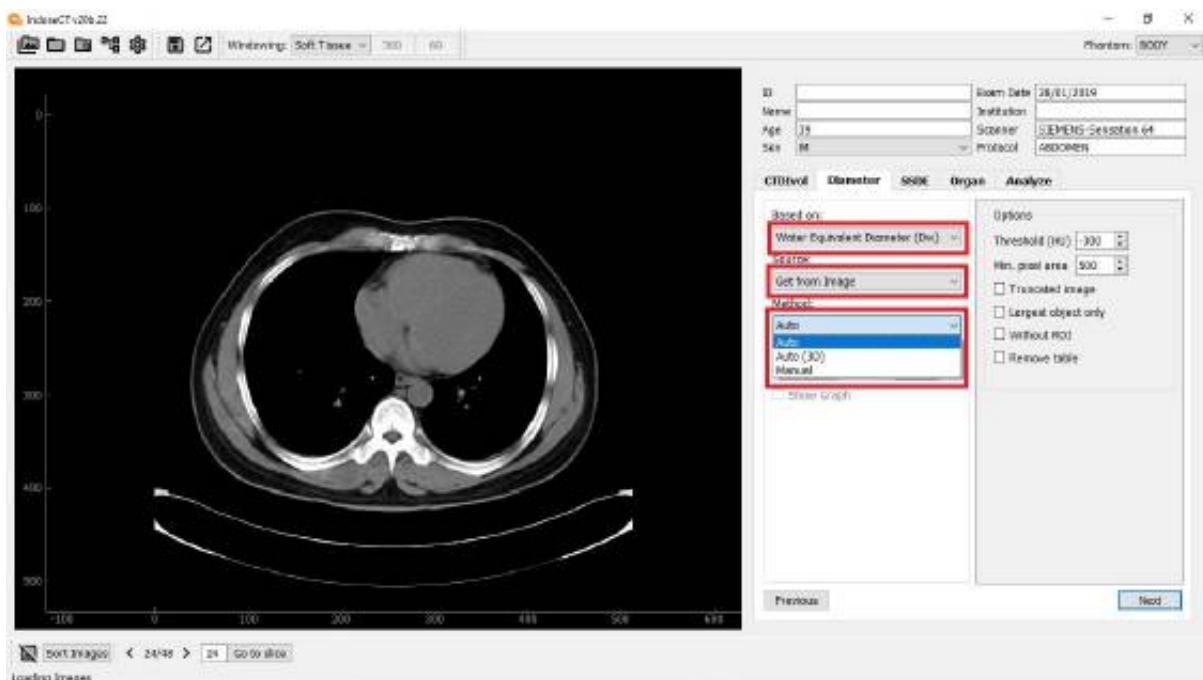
Calculation of D_w from the image. There are three choices of methods, namely: Manual, Auto, and Auto (3D). To use the Get From Image option, the user must have opened a CT image in DICOM format.
